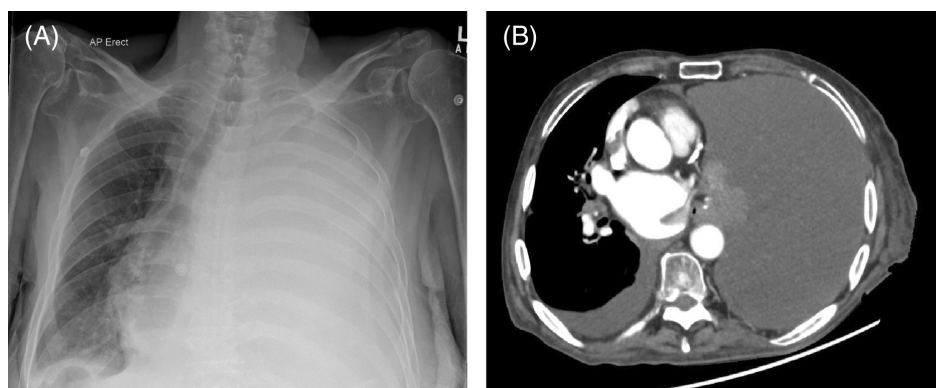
(A) Initial chest x-ray demonstrating complete opacification of the left hemithorax. (B) CT chest confirming the presence of a massive left pleural effusion.
